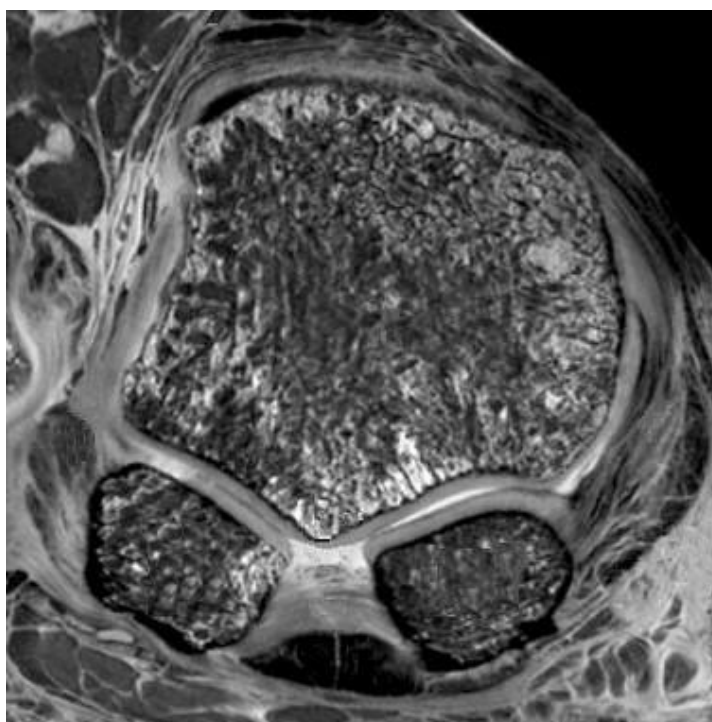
Nuclear magnetic resonance image of the first metatarsosesamoid joint in coronal plane.
